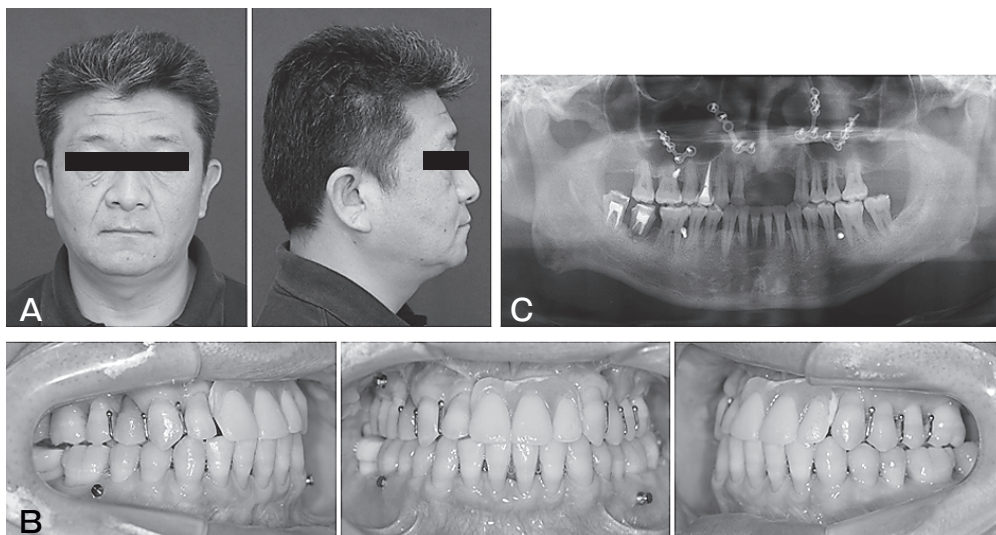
Post-treatment views. A, Facial photographs; B, Intraoral photographs; C, A panoramic radiograph.
